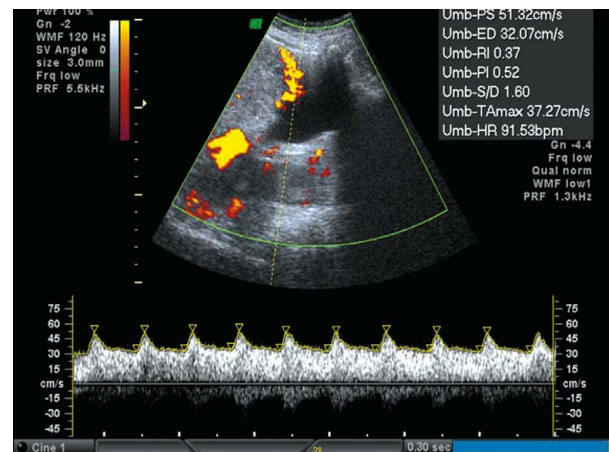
Sagittal transabdominal color Doppler ultrasound image showing uterine serosa-bladder interface hypervascularity with low-resistant (resistance index, 0.37), neovascularized arterial flow extending into the bladder.
